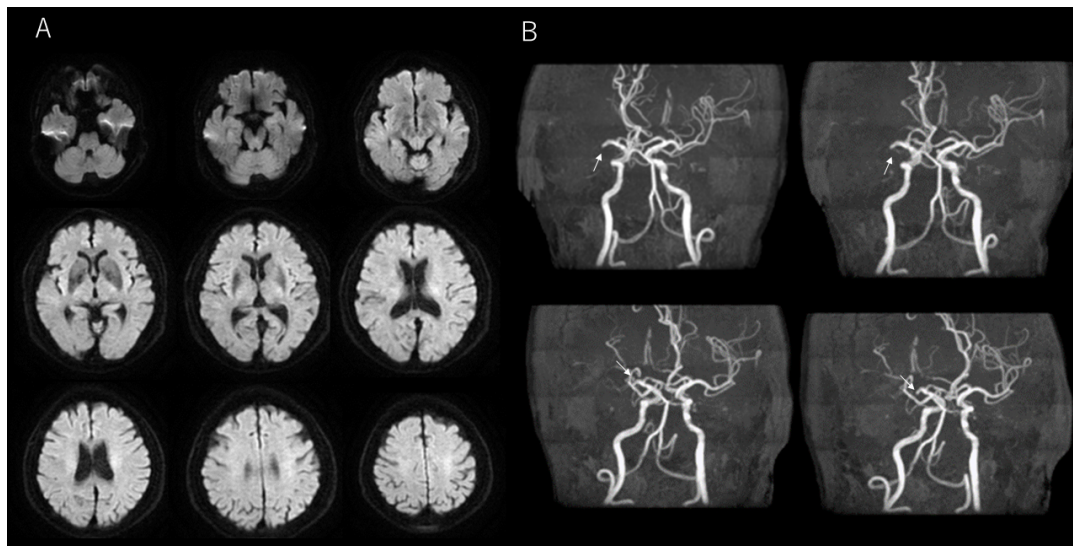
MRI and MRA. Axial diffusion-weighted imaging showed no abnormality (A), however magnetic resonance angiography indicated the right middle cerebral artery occlusion(B).
